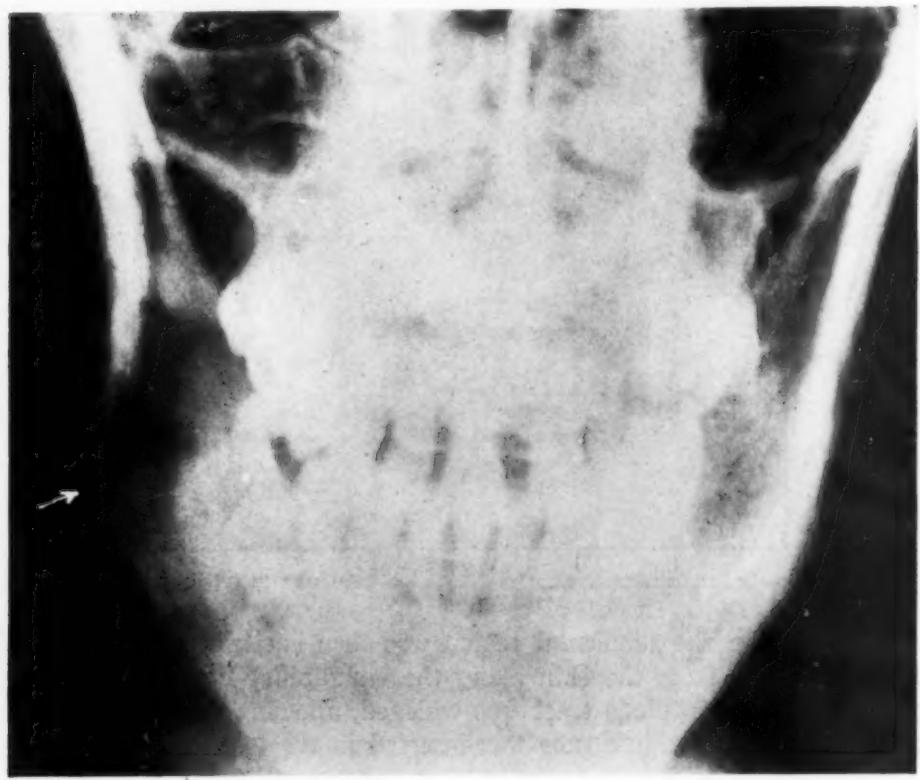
Anteroposterior roentgenogram six weeks after operation.
